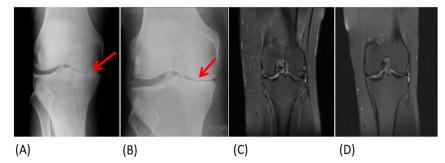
(A) X-ray image of a patient pre-injection with VAS score 8 (gross reduction of medial joint space); (B) X-ray image of a patient post-injection with VAS score 2 to 3 (improved medial joint space indicating cartilage regeneration); (C) MR image of knee pre-injection showing KL grade III; (D) MR image of knee post-injection showing KL grade II [all the images are of same patient]. The red arrow is showing improvement to the clinical outcome.
